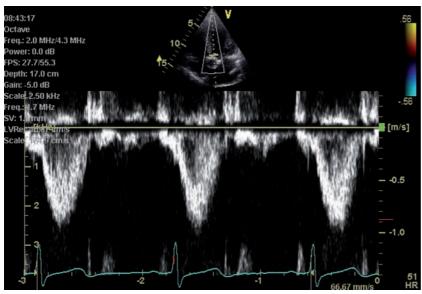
Pulsed wave Doppler echocardiogram in patient with severe aortic stenosis: transthoracic, two dimensional, apical, five chamber view (inset). A pulsed wave Doppler region of interest (sample volume) is placed proximal to the stenotic aortic valve in the left ventricular outflow tract, and the spectral display is shown. At 1.0 m/s, the blood flow velocity in the left ventricular outflow tract is equivalent to a gradient of 4 mm Hg
